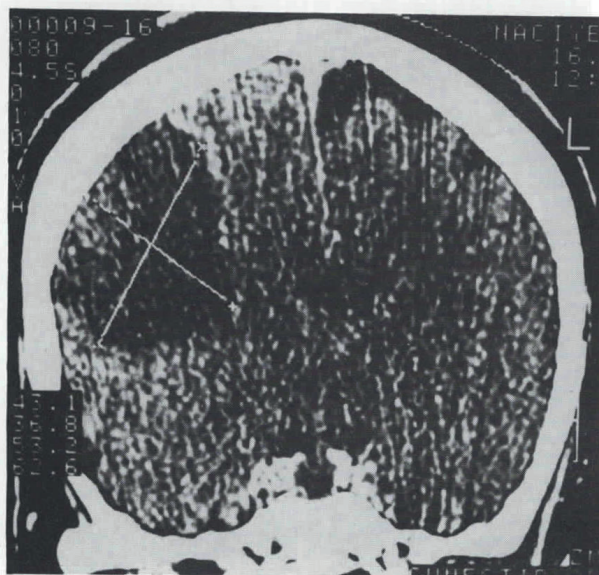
(Case 3) Postcontrast CT scan shows a parietal cystic lesion with a small isodense part.
